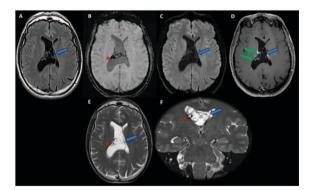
Brain magnetic resonance imaging (MRI) on axial FLAIR (A), SWI (B), diffusion (C), T1 post-contrast (D), and axial (E) and coronal (F) T2-weighted images. Large multiseptated cystic lesion (blue arrows) centered in the right lateral ventricle body and pushing away the septum pellucidum and the choroid plexus. There were signs of prior hemorrhage with multiple hemosiderin foci within the lesion and lateral ependymal wall (red asterisks). The only detected enhancement was related to the choroid plexus, and internal septations (green arrows).
